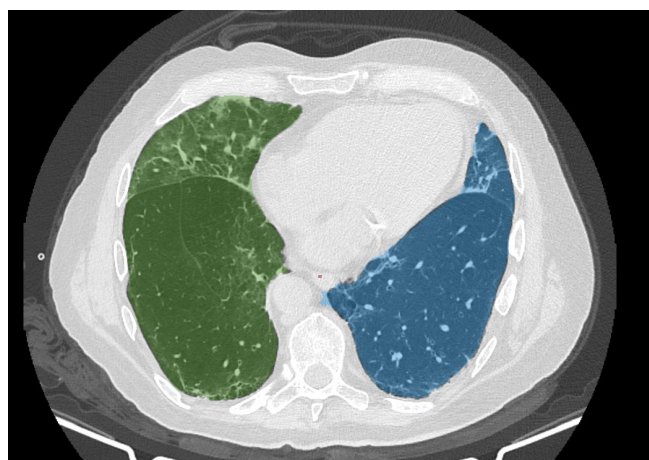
60 years old men admitted to the emergency room with fever and cough. MyrianÒ software XP-Lung application calculates right and left lung volume separately from axial CT images.
